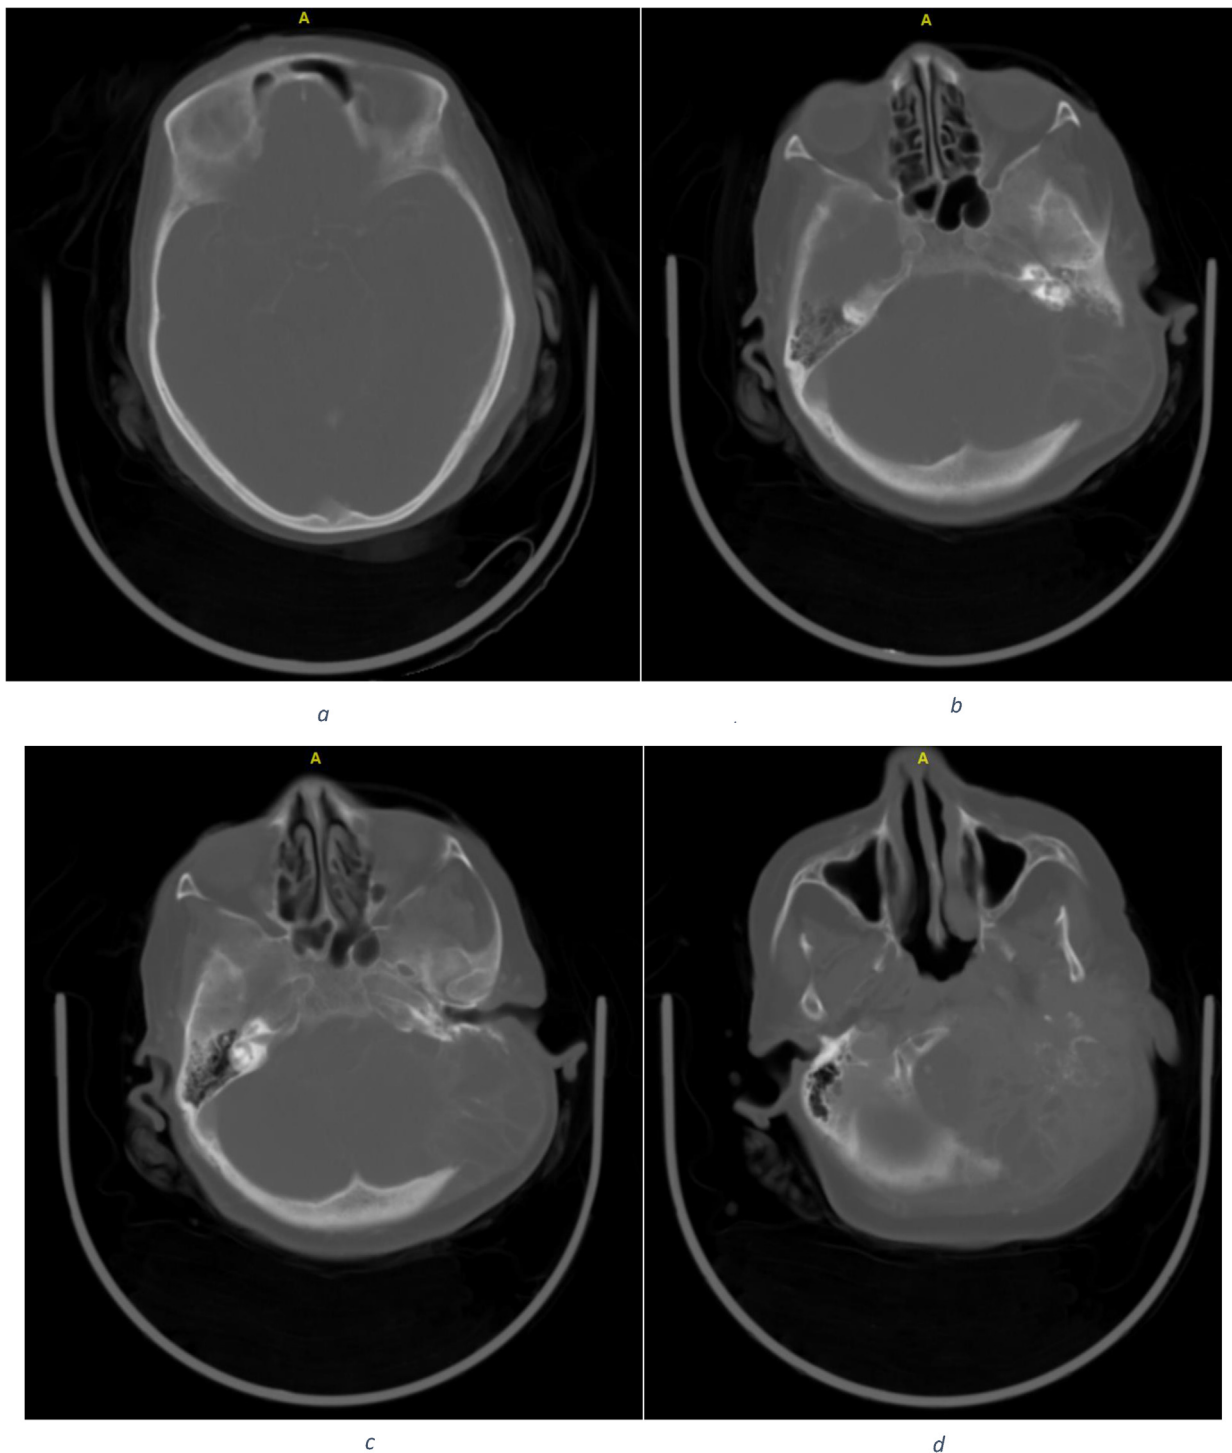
a–d: Computed tomography (CT) scan of the lesion.
